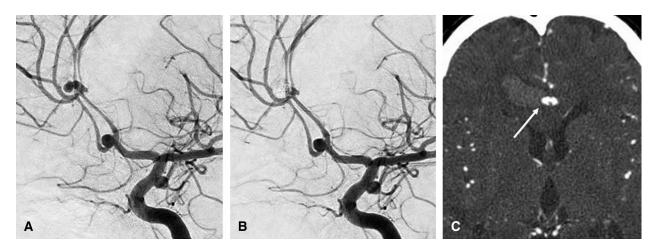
(A) Left internal carotid angiogram after 7 days of SAH, 3 years prior, showing the left distal ACA, Acom, and left internal carotid-Pcom aneurysms. (B) Post-embolization of the left distal ACA aneurysm. (C) CTA showing the small intracerebral hematoma including the dome of the distal ACA aneurysm. ACA: anterior cerebral artery, Acom: anterior communicating artery, CTA: computed tomography angiography, Pcom: posterior communicating artery, SAH: subarachnoid hemorrhage.
